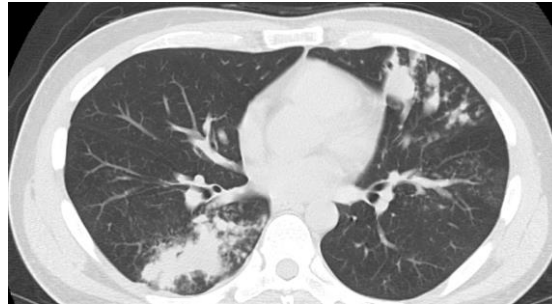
Computed tomography scans of the patient's chest of ABPA.
